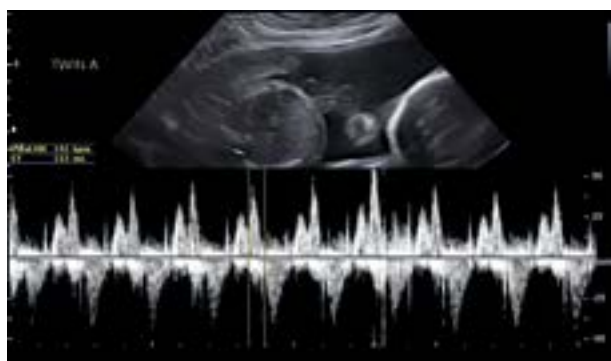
Normal fetal heart rate and sinus rhythm of Twin A on day 6 of antiarrhythmic therapy by Doppler interrogation of the left ventricle inflow and outflow
